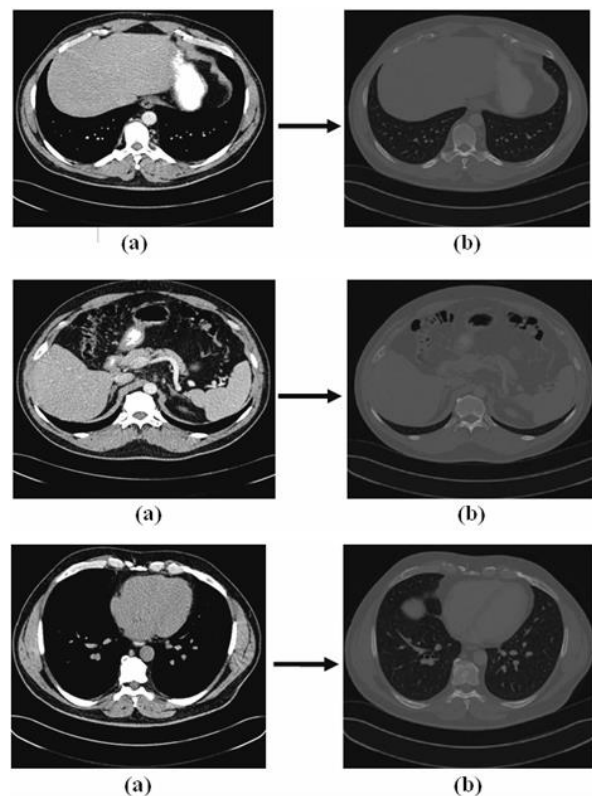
(a) Image of abdominal tissue slice by CT scanning (b) Image of abdominal tissue converted using MATLAB from CT image
